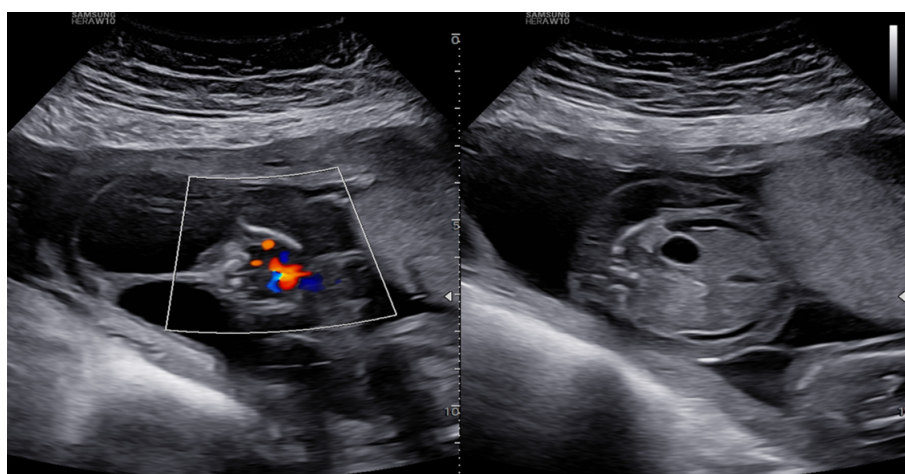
Fetal thorax with color Doppler of the heart showing marked extension of the nuchal edema (left). Fetal abdomen demonstrating the stomach in normal position with associated ascites (right).
